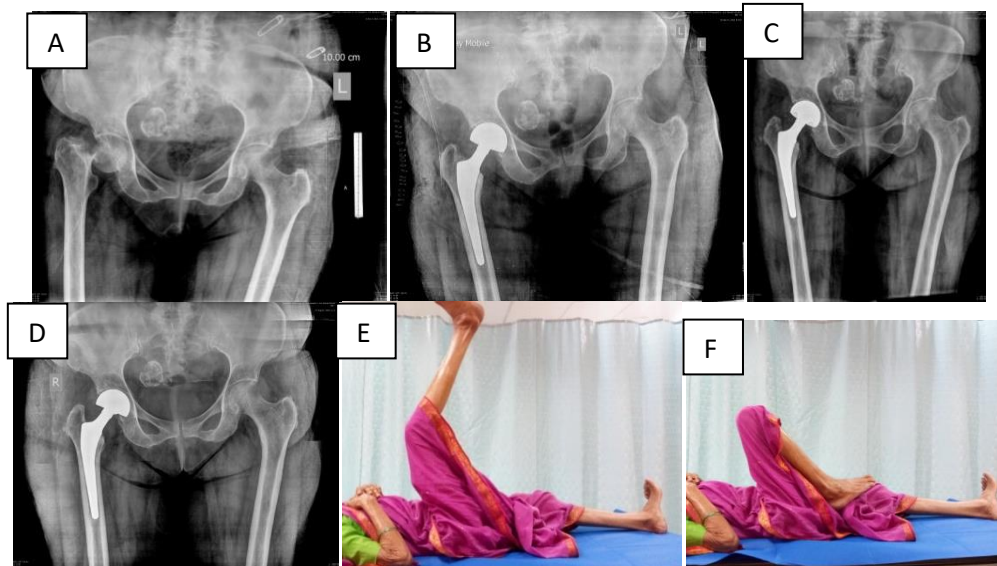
(A) 78 Year's Old Female with Garden Type 4 Right Neck Femur Fracture (B) She Was Treated with Right Total Hip Replacement. (C, D) Follow-Up Radiograph at 6 Months and 1 Year (E) Active SLR at 1 Year Follow-Up. (F) Range Of Motion at 1 Year.
